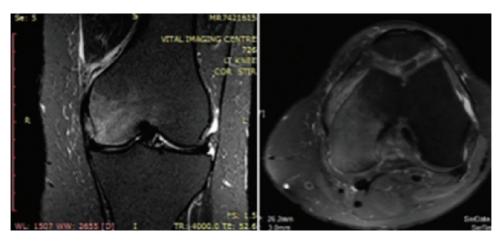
Pretreatment MRI T2W coronal and axial sections of the knee joint showing bone edema involving about 90% of the medial femoral condyle.
